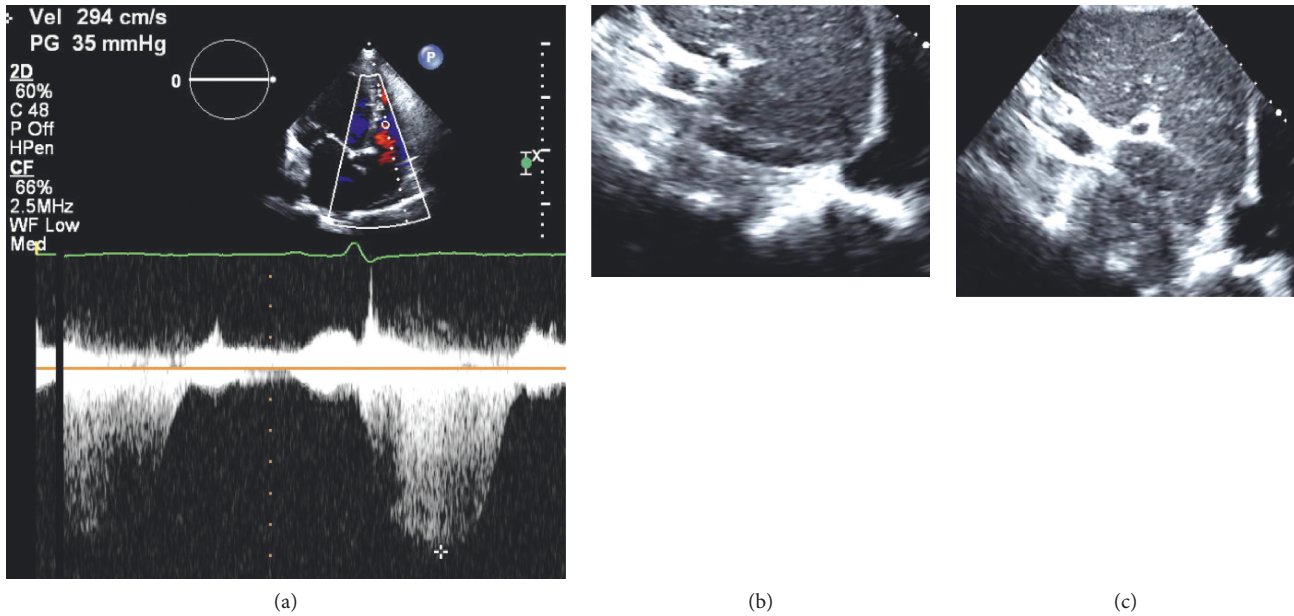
Transthoracic echocardiogram to determine right ventricular systolic pressure (RVSP). (a) Continuous-wave Doppler measurement of peak tricuspid regurgitant velocity of 2.9 m/s. Right ventricular systolic pressure is calculated via the modified Bernoulli equation $\Delta P_{TV} = 4 \times (V_{TR})^2$ or $\Delta P_{TV} = 4 \times (2.9 \text{ m/s})^2 = 34 \text{ mmHg}$. A small inferior vena on expiration (b) that completely collapses on inspiration (c) consistent with a mean right atrial pressure of 5 mmHg.
